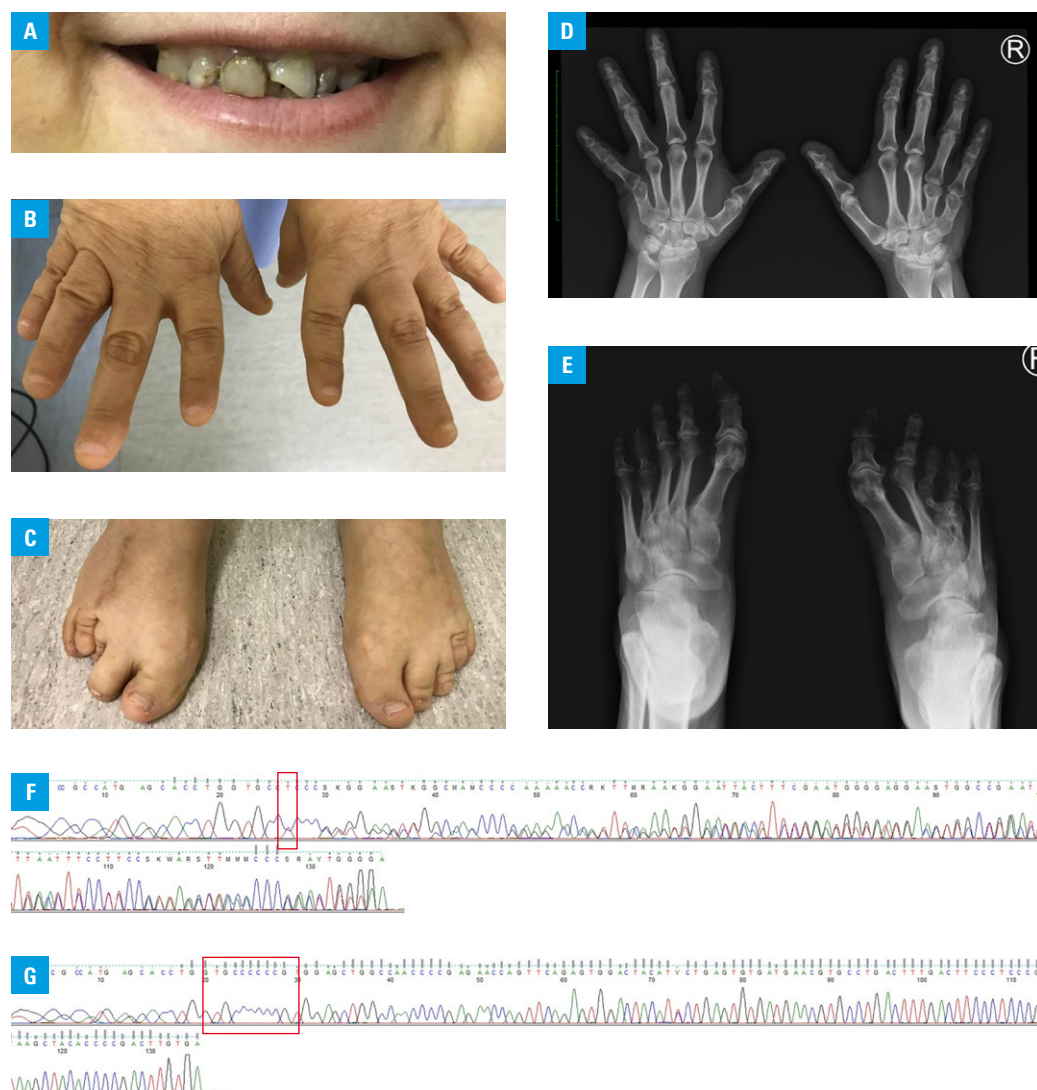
Clinical presentation of a female patient with pseudohypoparathyroidism type 1a and Albright hereditary osteodystrophy caused by a mutation in exon 5 of the *GNAS* gene; A – dental abnormalities with enamel hypoplasia; B, C – congenital skeletal deformations, including shortness of fingers and toes (first and fourth fingers of the left hand, fourth and fifth fingers of the right hand, third and fourth toes of the right foot, and fourth toe of the left foot) and a scar on the right foot due to orthopedic surgery; D, E – X-ray showing shortness of the metacarpals (fourth and fifth metacarpals of the right hand and first and fifth metacarpals of the left hand) and metatarsals (third and fourth metatarsals of the right foot and fourth metatarsal of the left foot); F – Sanger sequencing showing the c.344_345insT p.(Val117ArgfsTer23) mutation in exon 5 of the *GNAS* gene; G – the absence of the *GNAS* gene mutation in the patient’s mother
